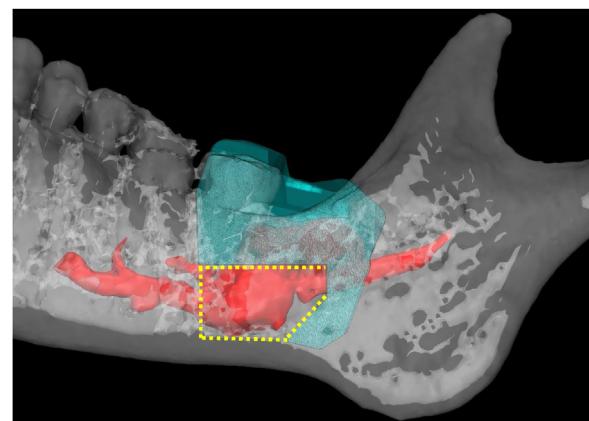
The 3D image showing mandible with traumatic neuroma fused between CT and MRI, and planned form of surgical guide.
